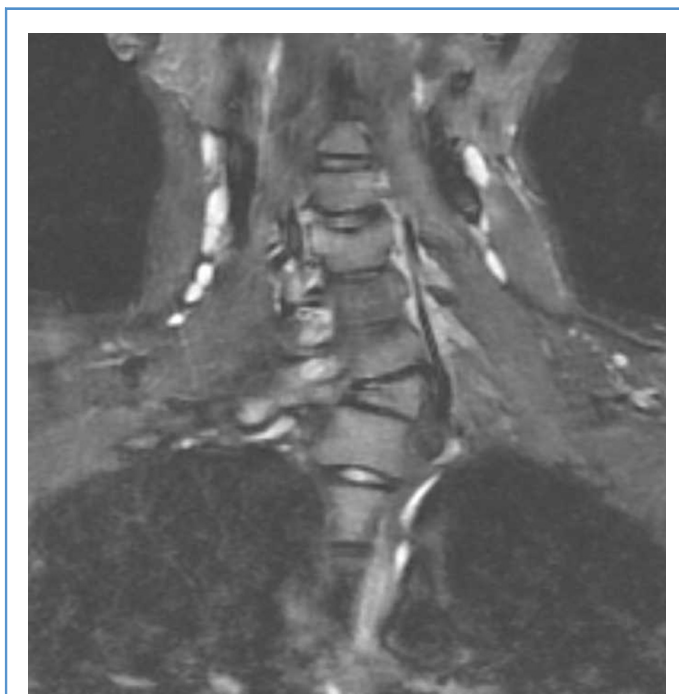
Coronal short-T1 inversion recovery magnetic resonance image (MRI) 10 years after the last treatment showing no residual tumor, cystic or solid. The right facets at C6/C7 and C7/T1 have fused.
